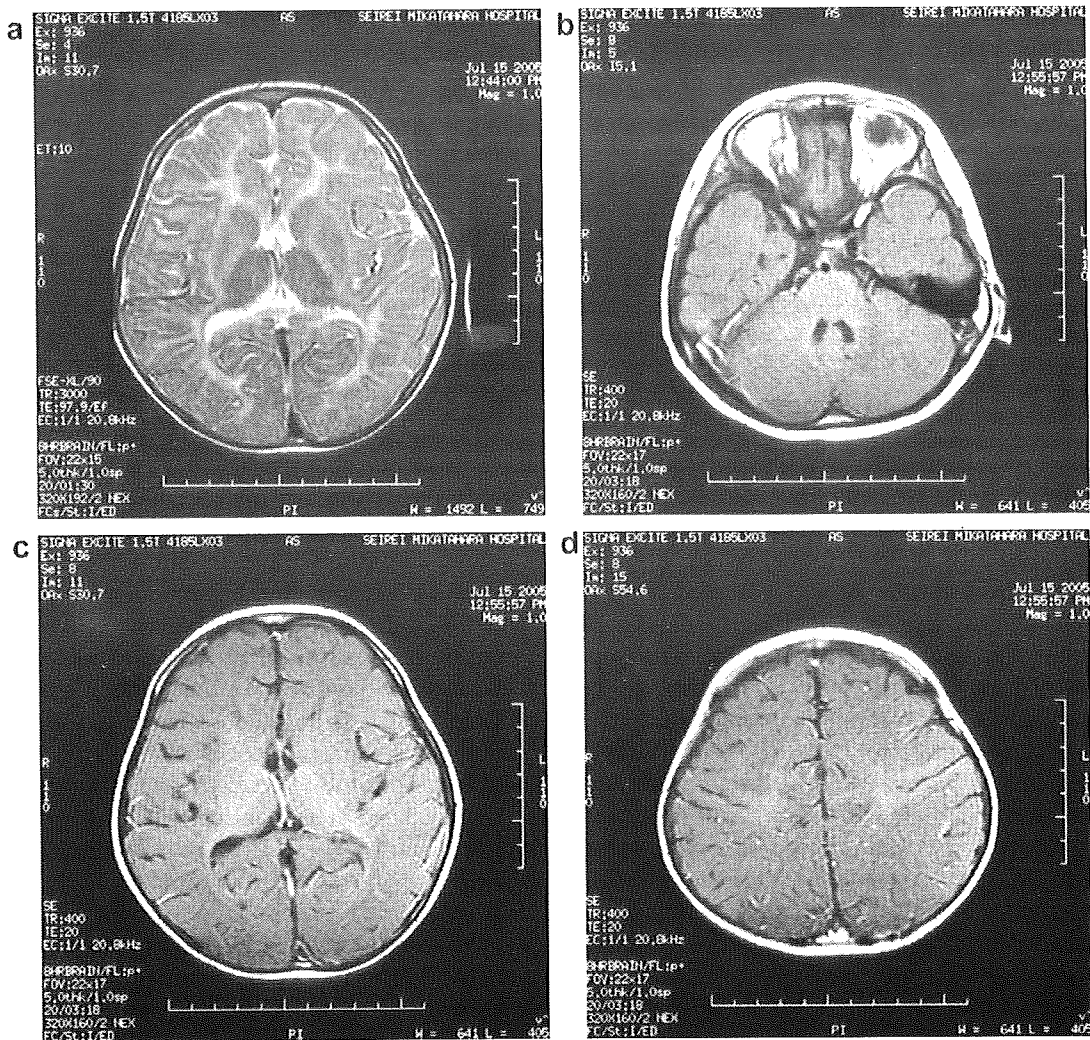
(a) Axial T2-weighted MR image at 2 years 8 months of age. A diffuse, symmetric signal abnormality involving most of the cerebral white matter is noted, with sparing of small portions of the posterior limbs of the internal capsule. (b–d) Axial T1 image at 2 years 8 months of age. Signal increase is present in the basilar region of the pons, inferior and middle cerebellar peduncles, and part of the cerebellar white matter (b). The corona radiata and optic radiation exhibit signal increase. The posterior limbs of the internal capsule exhibit no signal increase (c). Mild signal increase is noted in the central sulcus (d).
